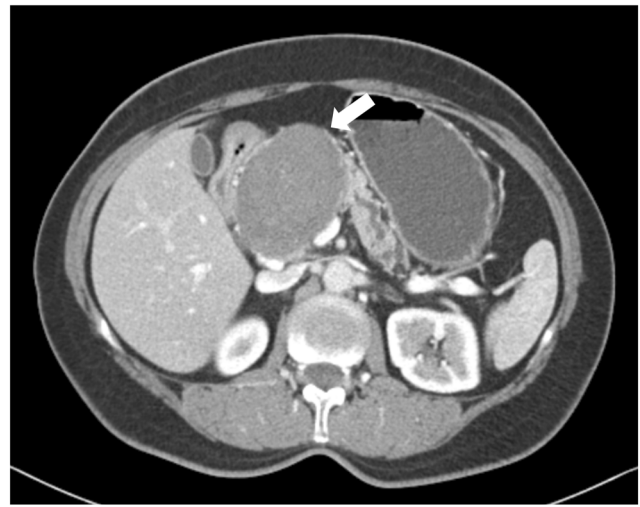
CT scan of a 61-year old female demonstrating a 8.4-cm well-circumscribed, homogenous mass arising from the head of the pancreas, with upstream pancreatic duct dilatation. The mass had several smaller foci of internal cystic changes with central necrosis. Presumed diagnosis was a pancreatic cystic neuroendocrine tumor
